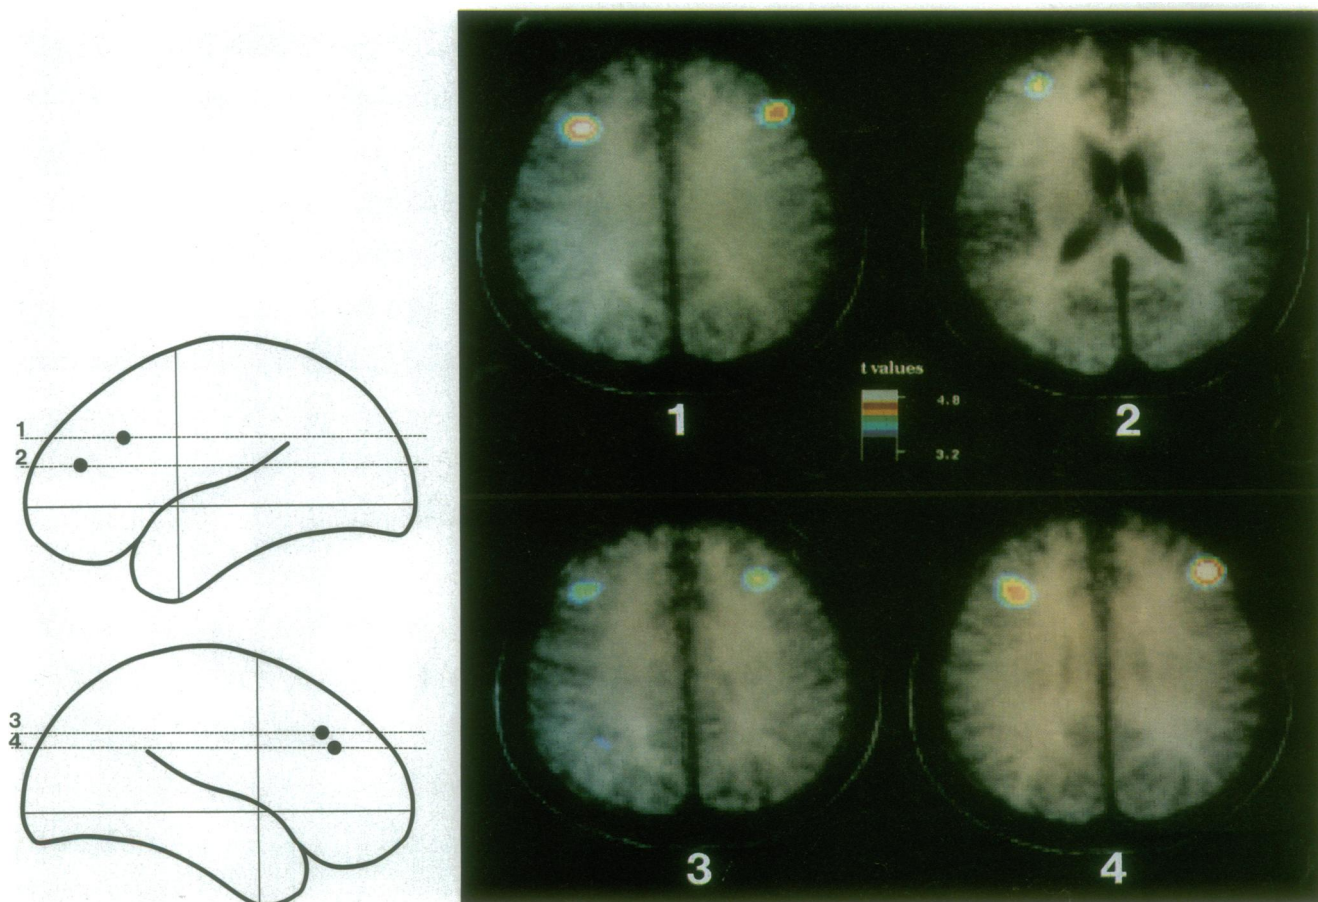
Externally ordered minus control task. Merged PET-MRI horizontal sections showing activation foci within the mid-dorsolateral frontal cortex. The coordinates (x, y, z) of the foci shown on the outlines of the brain are 1, 35, 24, 31; 2, 32, 44, 18; 3, 27, 29, 36; and 4, 40, 34, 29.
